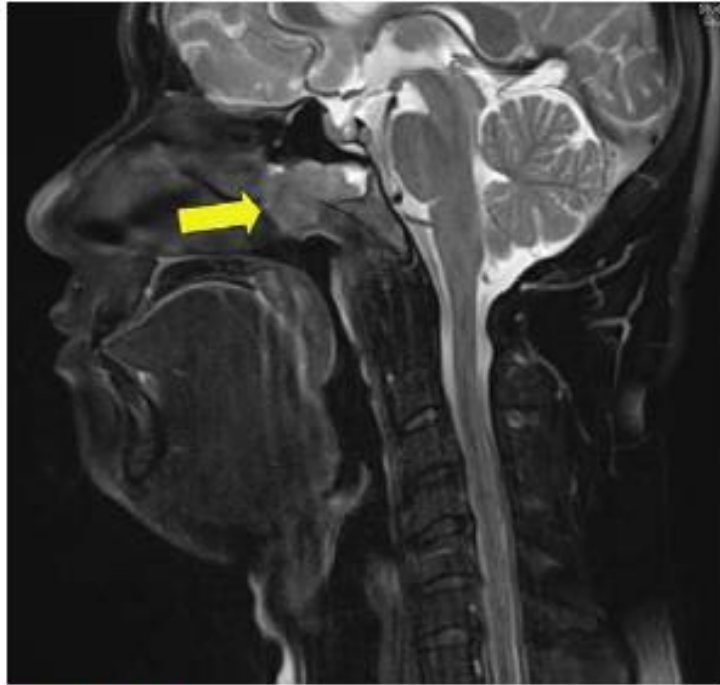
Sagittal T2-weighted MRI demonstrates NPC invading the sphenoid sinus (arrow).
